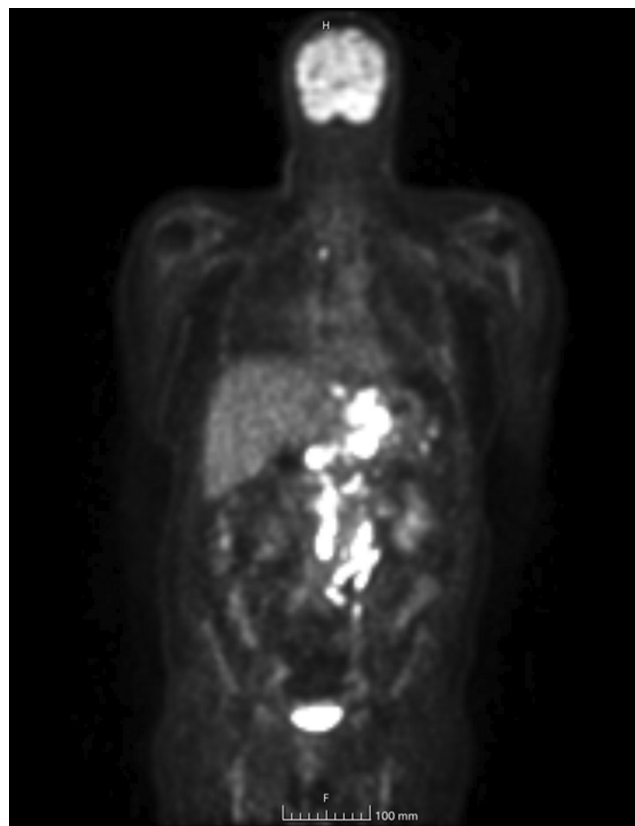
FDG PET scan demonstrating macro area of intense hypermetabolism in esophago-gastric region extended to the small gastric curvature and multiple areas of intense glucose hypermetabolism, some confluent, of abdominal lymph node relevance.
